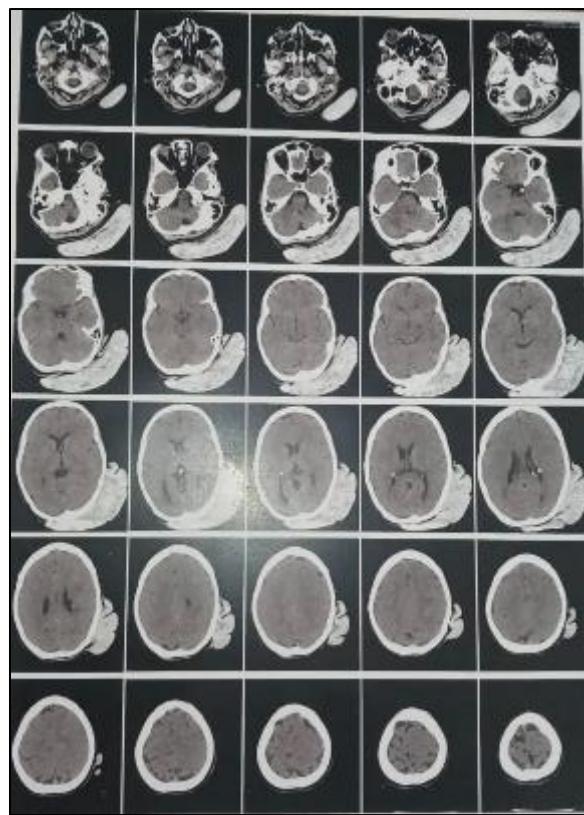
Brain CT scan showing parieto-occipito-temporal hamartoma.
